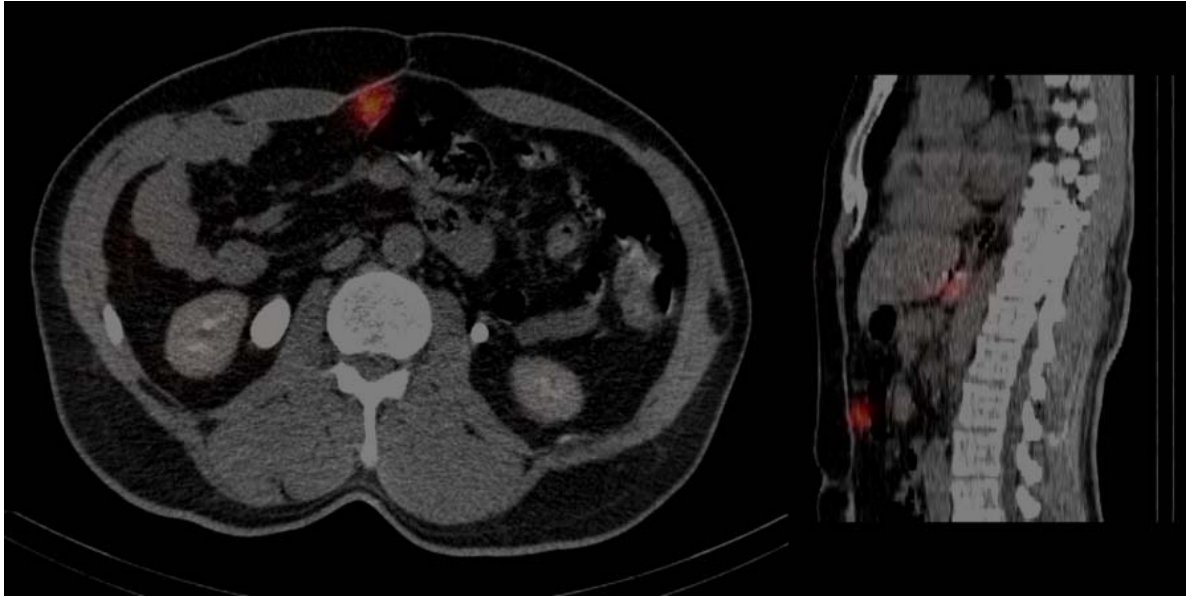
58 year-old male with a history of metastatic neuroendocrine disease with hepatic involvement was administered 173.9 MBq of ^{99m}Tc -MAA through a microcatheter placed the middle hepatic artery. The transaxial and sagittal reconstructed SPECT/CT image shows ^{99m}Tc -MAA uptake within the anterior abdominal wall due to flow from the falciform artery, which originated from the middle hepatic artery.
